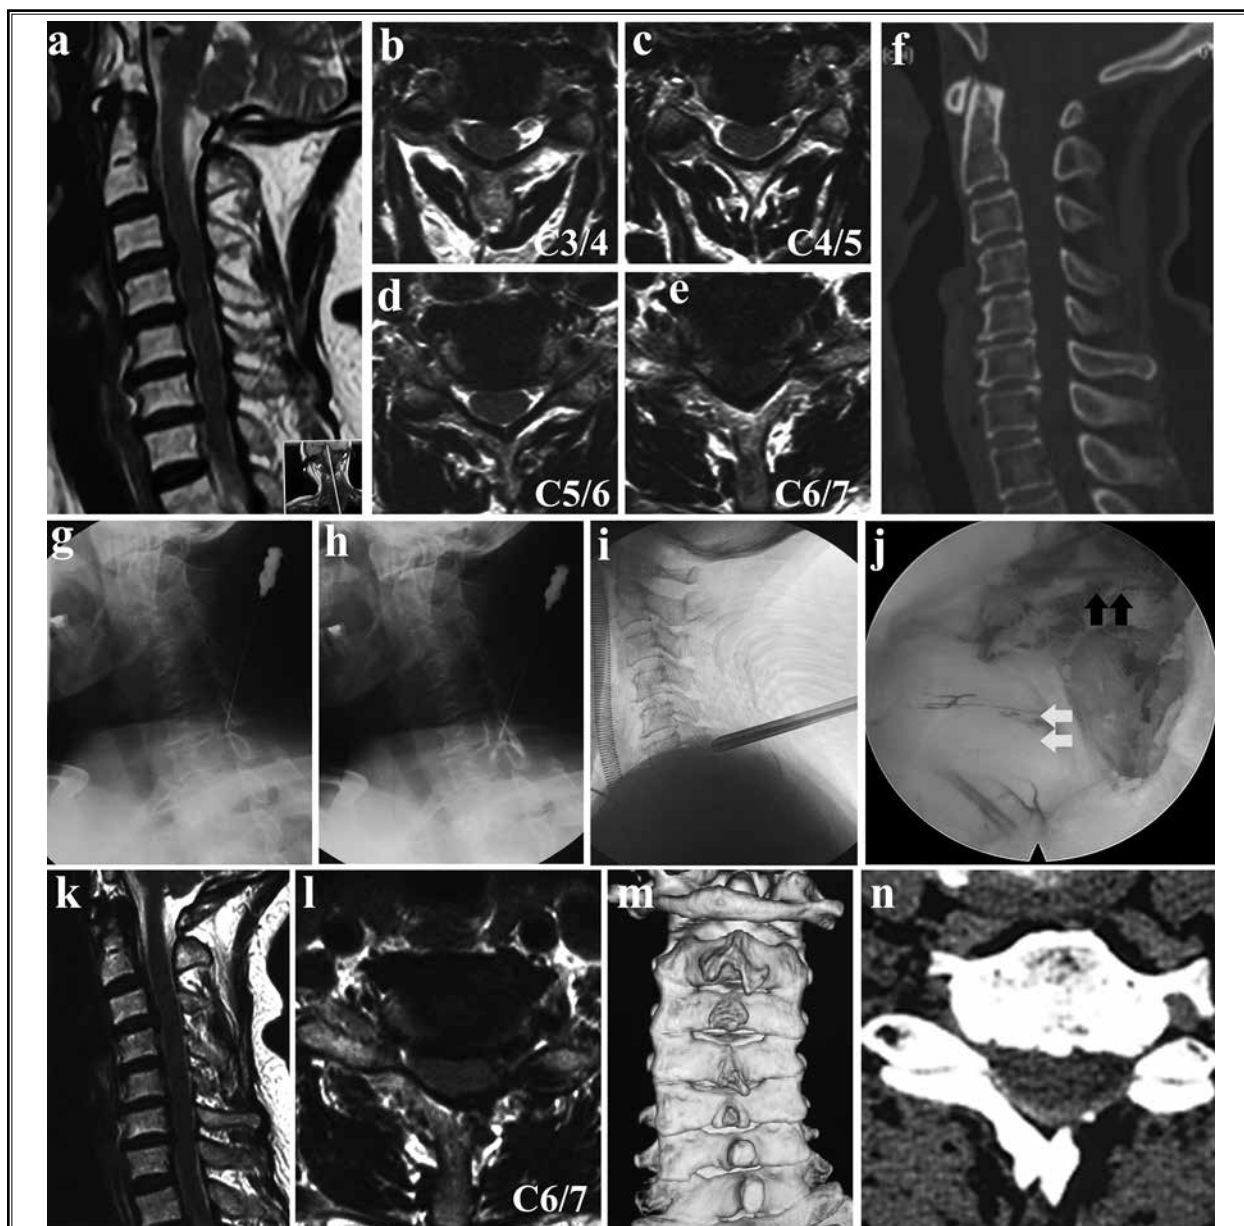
A 70-year-old woman presented with neck, shoulder, and left arm pain radiating to the ulnar side. The T2-weighted (A) sagittal and (B–E) axial MRI show multilevel disc herniation at the C3/4, C4/5, C5/6, and C6/7 levels. (F) Preoperative CT scan shows no calcification and ossification. (G, H) An SNRB was performed on the left side of the C7 nerve root. The pain was alleviated over 80%. (I) Placement of the working channel on the C6/7 level. (J) Freed cervical dural sac (black arrow) and nerve root (red arrow) after full decompression. (K, L) Postoperative (6 months) MRI scans demonstrate removal of the disc and decompression of the dural sac at the C6/7 level. (M, N) Postoperative view of 3D reconstruction and axial CT scan show the keyhole decompression field.
